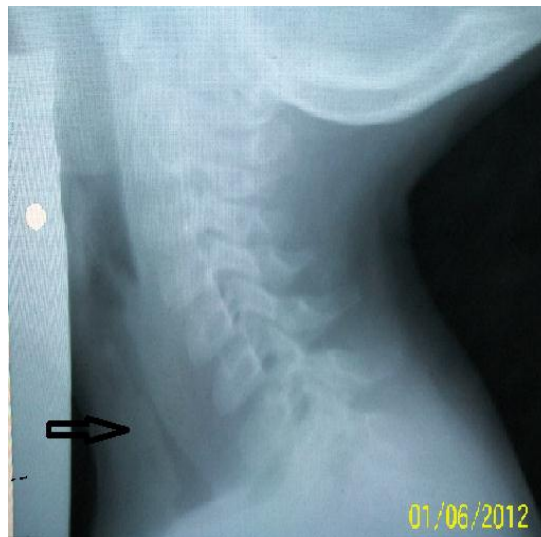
Lateral neck X-ray view of the patient showing subglottic narrowing and soft tissue opacity.
